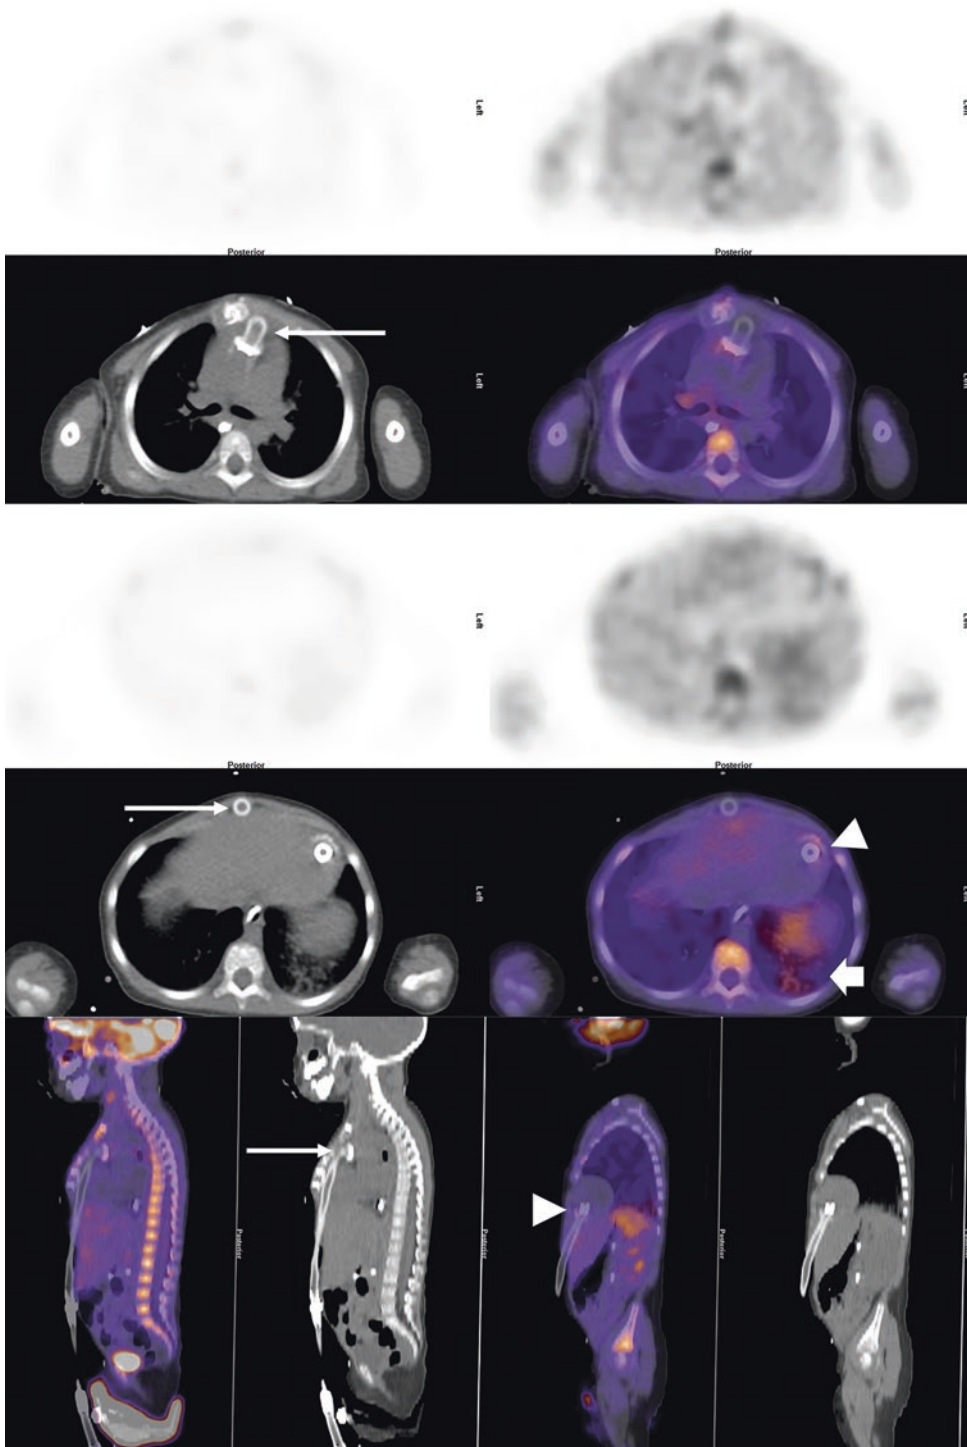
^{18}F -FDG PET/CT was performed in a 1.5-year-old girl with a history of recurrent fever and known Berlin Heart, a left ventricular assist device (LVAD). There was evidence of pneumonia in the left lung base (open arrow).
